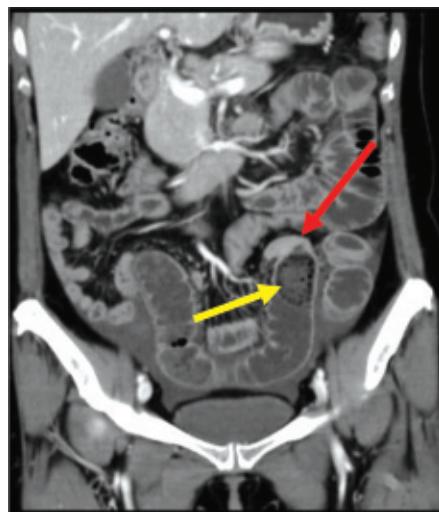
SB feces sign; coronal view of CT abdomen shows fecal material within the SB (yellow arrow), which usually signifies the site of obstruction (red arrow).
